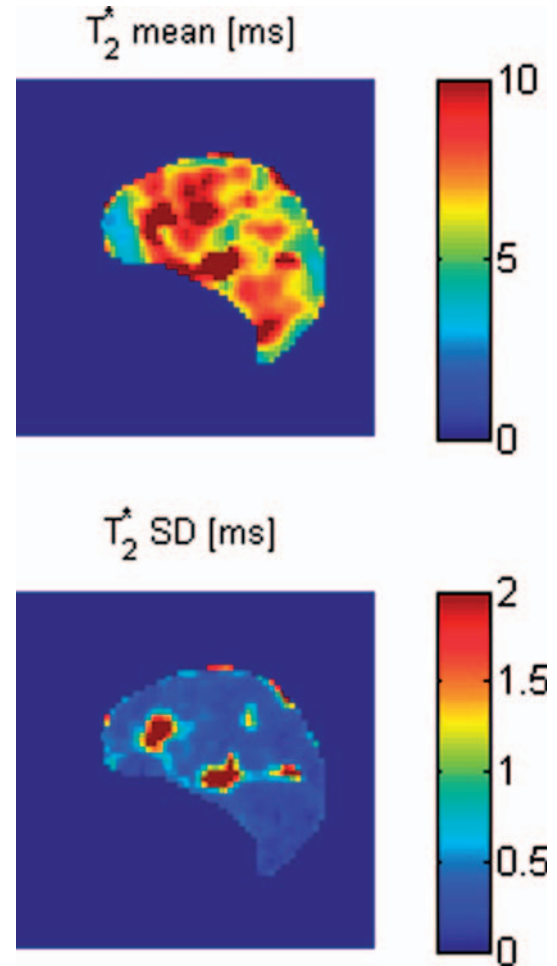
BOLD MRI parametric maps of T_2^* mean and SD for a control tumour.
